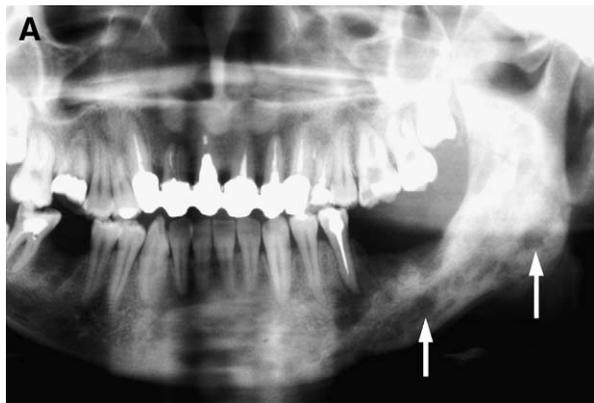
A, Panoramic radiograph of left mandible with osteomyelitis in SAPHO syndrome. Osteolytic areas (arrows) are observed in areas with severe sclerotic changes (mixed pattern). B, More than 5 years after the radiographs in A were taken, the left mandibular bone volume has been reduced by bone resorption on external bone surfaces and osteosclerotic changes are prominent.
